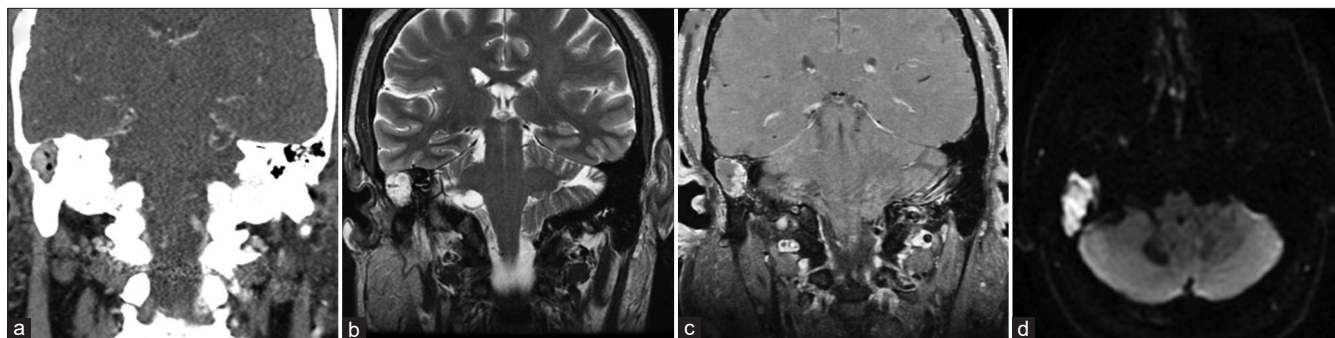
A case of a 17-year-old patient with a delayed presentation of a cholesteatoma after initially presenting as a trauma from a motor vehicle accident and right sided otorrhea. (a) Computed tomography scan demonstrated 2 cm mass in the right medial aspect of the external auditory canal involving the right mastoid consistent with a cholesteatoma. (b-d) Magnetic resonance imaging of the lesion demonstrating, (b) T2 signal hyperintensity, and (c) mild irregular peripheral enhancement on T1 sequences with contrast. (d) DWI sequences demonstrating avid diffusion restriction, a characteristic feature of cholesteatomas.
